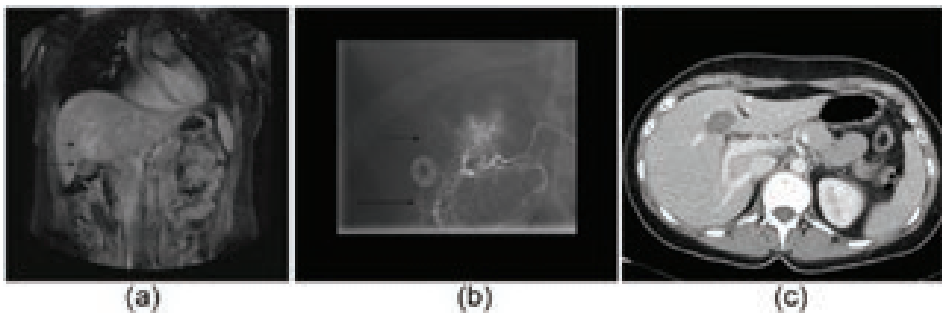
A 25-year-old female with a MRI diagnosis of single HCA, probably inflammatory subtype. As the patient wished to become pregnant, despite growth of her HCA, a decision to treat with TAE was taken. Coronal MR image with T1-weighting of the upper abdomen (a). A hypervascular HCA is indicated (small arrow), adjacent to the gallbladder (long arrow). Ablation was contraindicated due to the close proximity of the gallbladder. Angiogram (b) before TAE showing an arterial tumor 'blush' in the HCA (short arrow), with the gallbladder perfused by the same local hepatic artery division (long arrow). This finding contraindicated TAE due to the possibility of gallbladder necrosis following infarction. Instead, a decision to operate was made, with resection of the gallbladder, and subsequent intraoperative RFA of the HCA. Axial postoperative CT image after contrast injection in the venous phase (c). The gallbladder was resected, in combination with intraoperative RFA (arrow). CT, computerized tomography; HCA, hepatocellular adenoma; RFA, radiofrequency ablation; TAE, transcatheter arterial embolization.
